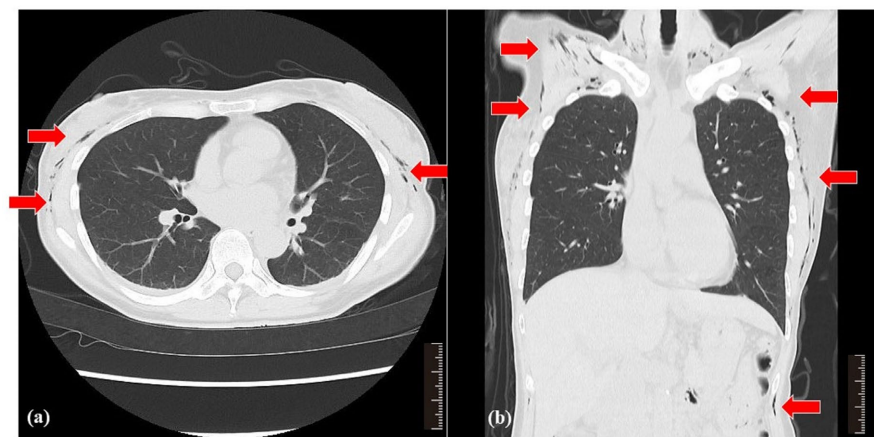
Chest computed tomography on postoperative day 1 showed persistent subcutaneous emphysema extending from the neck to the chest, without evidence of mediastinal emphysema.
